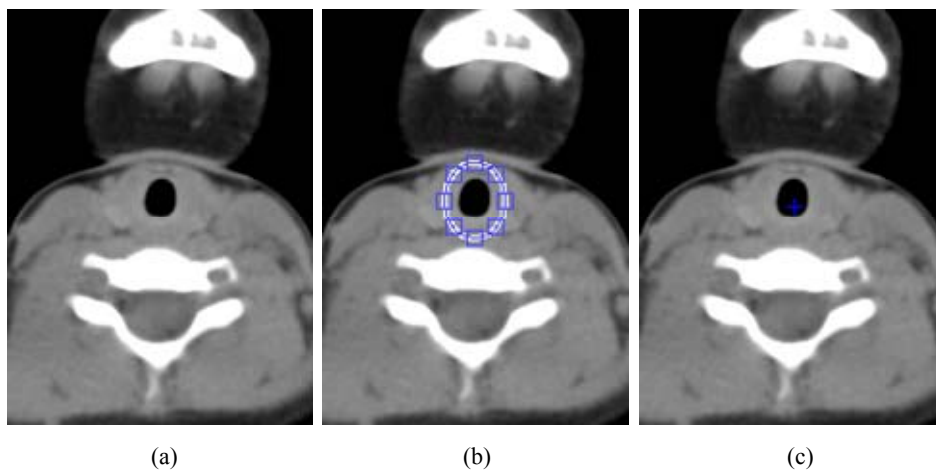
ROT identification, (a) initial CT slice (b) selection of initial ROT (c) starting from this ROT, the software locates the seed-point (see online version for colours)
